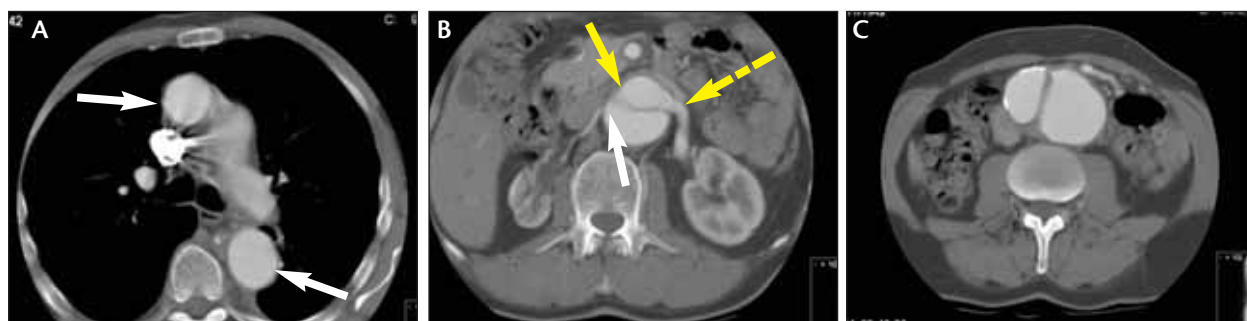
CT scan shows replacement of the ascending and most of the descending aorta that are of normal caliber (white arrows) (A). Large thoracoabdominal dissection is seen with a large proximal fenestration (solid yellow arrow). The left renal artery is seen to come off the true lumen (dashed yellow arrow) and the right renal artery off the false lumen (white arrow). The right kidney is also seen to be atrophic (B). The infrarenal aorta is seen to be aneurysmal, which consists mainly of the enlarged false lumen (C).
